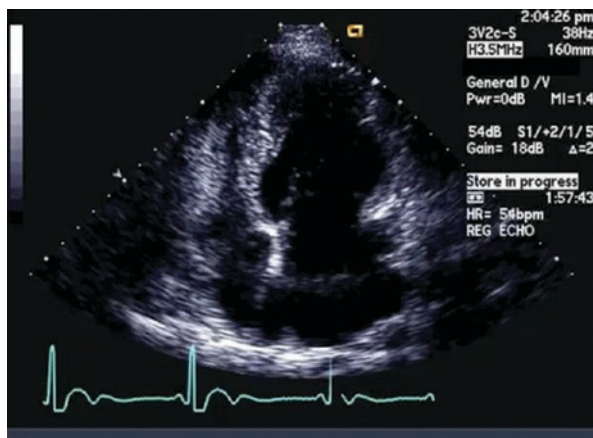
shows an unenhanced apical four-chamber view demonstrating an enlarged LA and normal-sized right atrium (RA) and right ventricle (RV) with normal RV contractility. Only the basal segments of the LV were seen, and they appeared to have normal contractility; however the apical segments were not well visualized.
